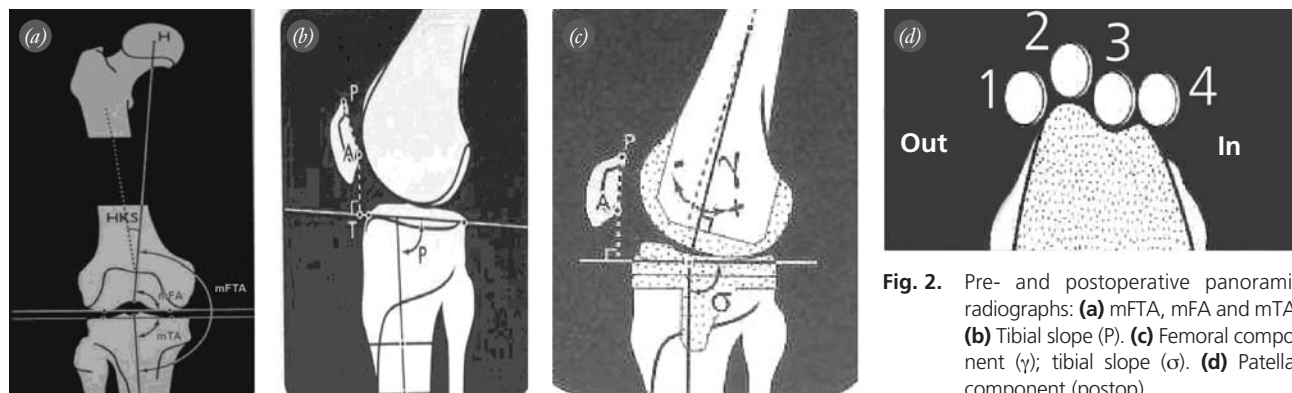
Pre- and postoperative panoramic radiographs: (a) mFTA, mFA and mTA. (b) Tibial slope (P). (c) Femoral component (γ); tibial slope (σ). (d) Patellar component (postop).
